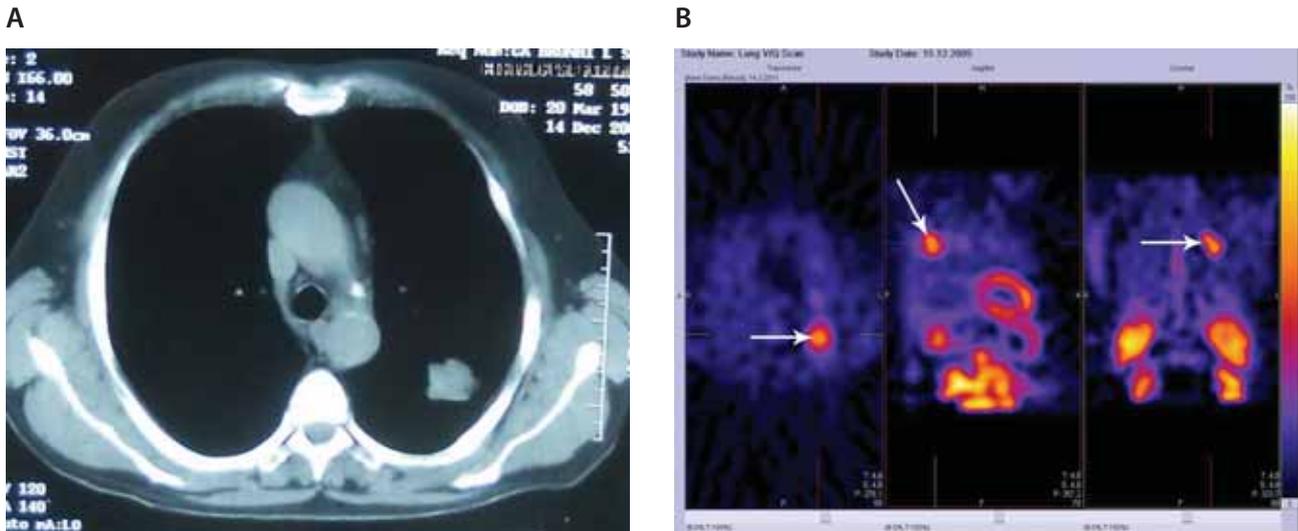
(A) CT scan of the chest of 59 year-old male patient revealing a 3 cm nodule in the left upper lobe (posterior segment) of the lung. (B) ^{99m}Tc -MIBI SPECT scan in the same patient showing very intense accumulation of ^{99m}Tc -MIBI in the lung region corresponding to the localisation of the nodule. At surgery the nodule was found to be adenocarcinoma.
